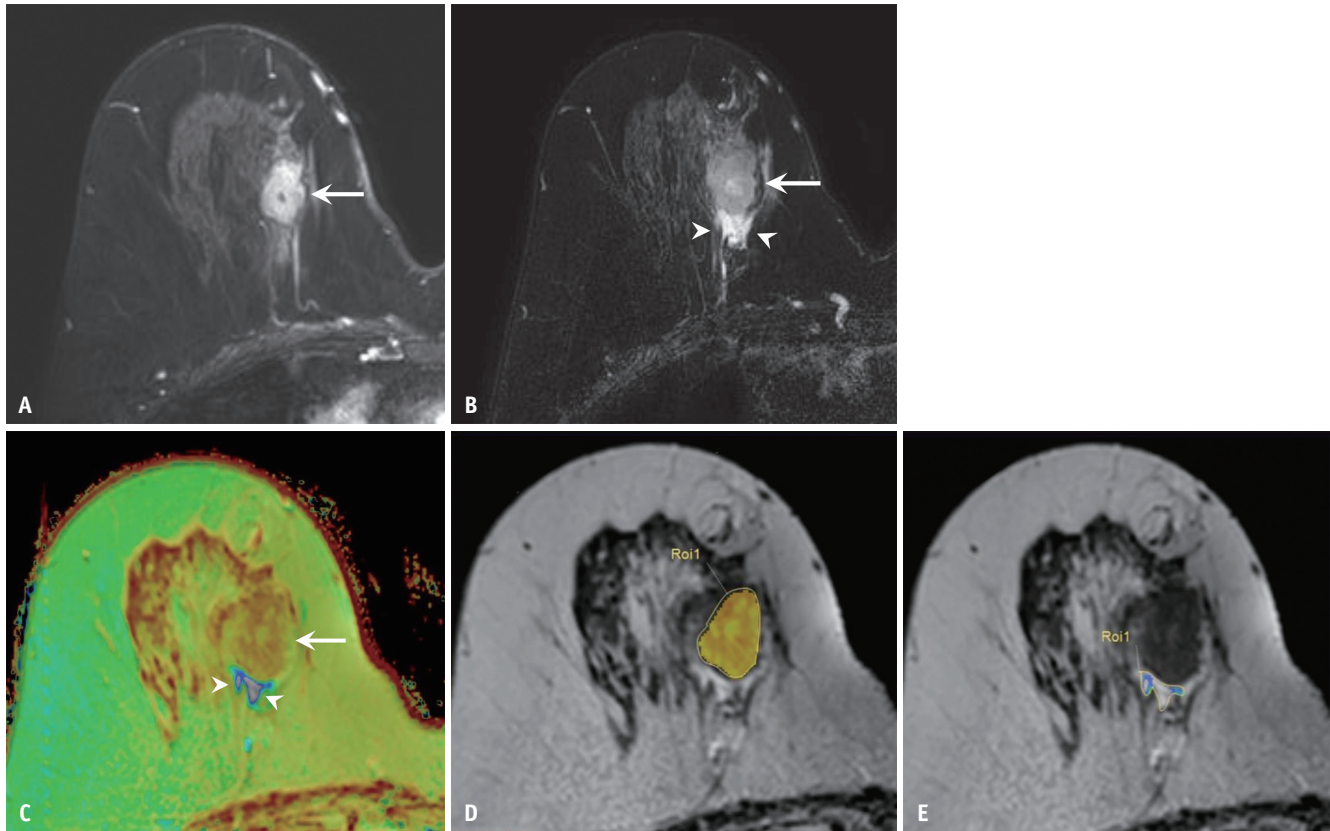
T2 relaxation time mapping in a 54-year-old woman with triple-negative invasive ductal carcinoma that achieved pathologic complete response after neoadjuvant chemotherapy. A: Fat-suppressed T1-weighted early contrast-enhanced axial image shows a malignant mass in the right upper inner breast (arrow). B: On the fat-suppressed T2-weighted axial image, the mass (arrow) demonstrates grade 1 intratumoral T2 signal intensity and grade 2 peritumoral edema (arrowheads). C: The T2 color map shows the mass (arrow) and adjacent peritumoral edema (arrowheads). D, E: Manual segmentation of the tumor (D) and the peritumoral edema area (E) was performed twice, and the mean of the two measured T2 relaxation times was used for analysis.
